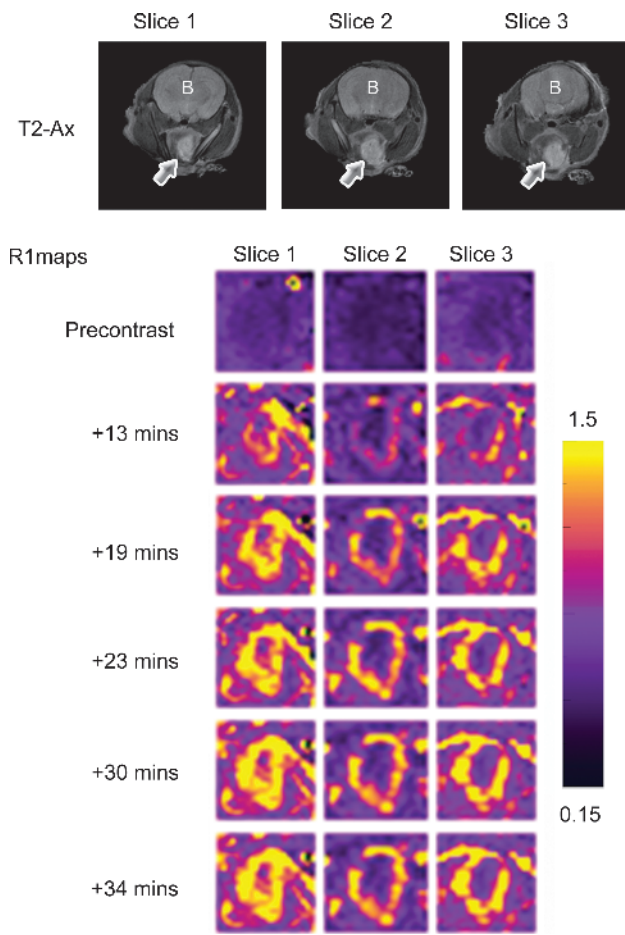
Contrast-enhanced MRI of orthotopic HNC xenografts. Axial T2W images and corresponding pseudocolored and binarized R1 maps ($R1 = 1/T1$) of serial slices of an orthotopic FaDu tumor showing a marked but heterogeneous pattern of enhancement during the postcontrast imaging period. The panels of images represent R1 maps calculated on a pixel-by-pixel basis from serial T1W images before (precontrast) and after (post contrast) contrast agent injection for ~40 minutes. *Arrows* indicate tumor; *B*, brain.
